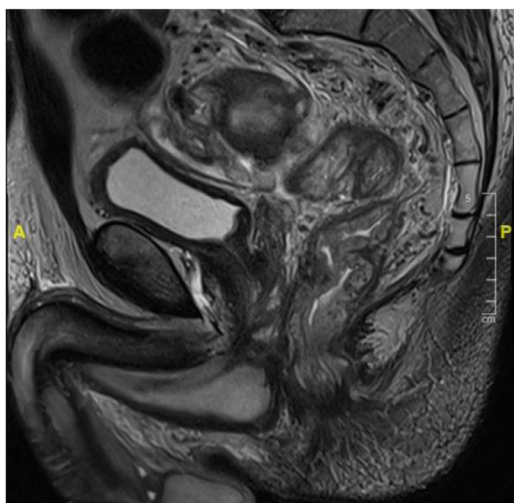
Magnetic resonance imaging after chemoradiation demonstrates no residual mass (mrTON0) with proctocolitis and perirectal edema.
